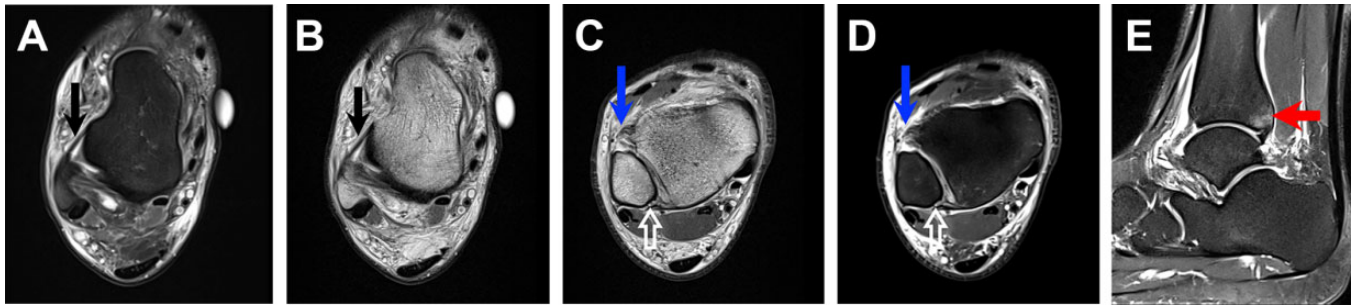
Example of magnetic resonance imaging (MRI) findings of high ankle sprains. (A, B) Axial intermediate and fat-suppressed T2-weighted MRI scans at the level of the anterior talofibular ligament (ATFL) demonstrating low signal intensity in the intact thin ATFL (black arrows). (C, D) Axial intermediate and T2-weighted fat-suppressed MRI scans at the level of the syndesmosis demonstrating a complete tear of the anterior-inferior tibiofibular ligament (thick blue arrows) and a partial stripping-type tear of the posterior-inferior tibiofibular ligament from the distal fibula (open white arrows). (E) Sagittal T2-weighted fat-suppressed MRI scan demonstrating bone bruising of the posterior tibial plafond (red arrow).
